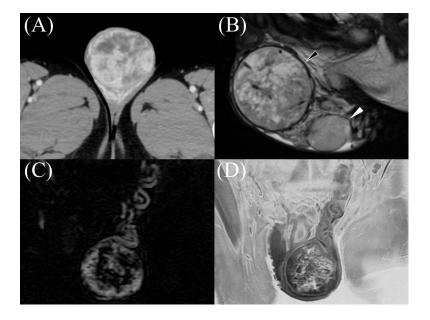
(A) Contrast-enhanced CT shows a 6 cm neoplasm with heterogeneous hypoattenuation and surrounding venous proliferations; (B) T2-weighed magnetic resonance image shows a scrotal mass with a thick capsule of low signal and a heterogeneous, high-signal interior (black arrowhead). The left testis is denoted by a white arrowhead; (C) The post-contrast dynamic study revealed a prominently dilated feeding artery and drainage veins, accompanied by rapid intratumoral enhancement starting from the periphery; (D) Fast field echo resembling a computed tomography scan using restricted echo-spacing.
